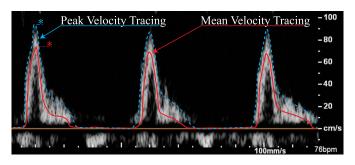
Example of the peak (blue dashed curve) and mean (solid red curve) velocity tracings of the PW Doppler spectra. The maxima (*) of each over the acquired heartbeats were used for the quantitative comparison with the peak echoPIV results.
